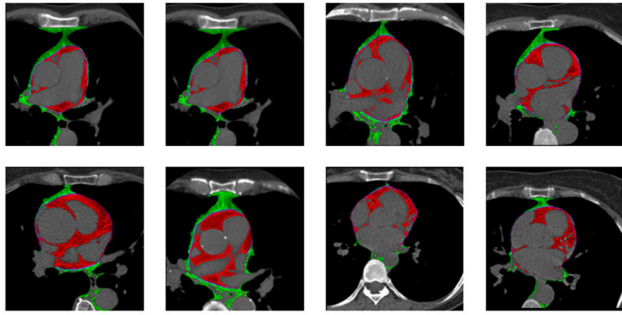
The sample CT images from 8 patients with different sizes, shapes and positions of the epicardial fat with red color.
